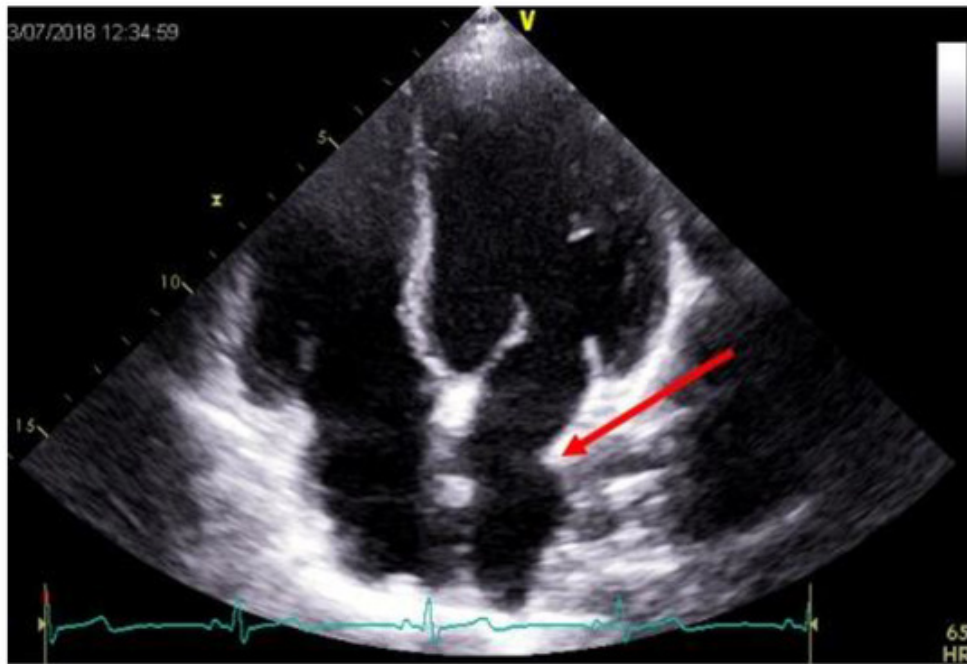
Echocardiography with Apical 4-chamber view after heart transplantation (Red arrow indicated the anastomosis between recipient and donor atria[123])
